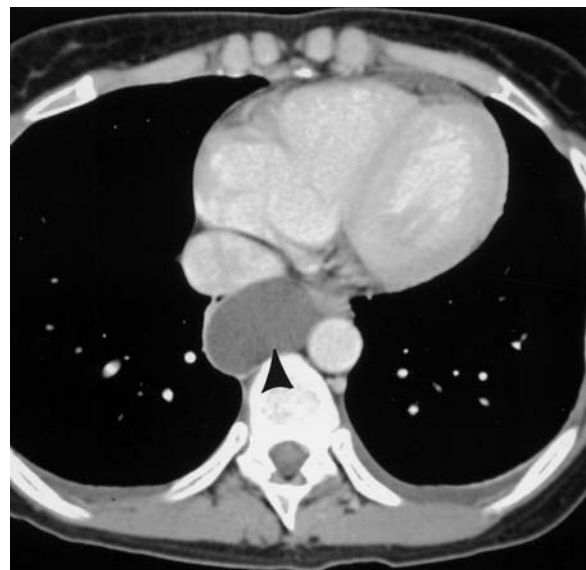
Enteric cyst. Axial contrast-enhanced CT shows a well-defined, homogeneous water-attenuation mass (arrowhead) filling the azygosoesophageal recess
